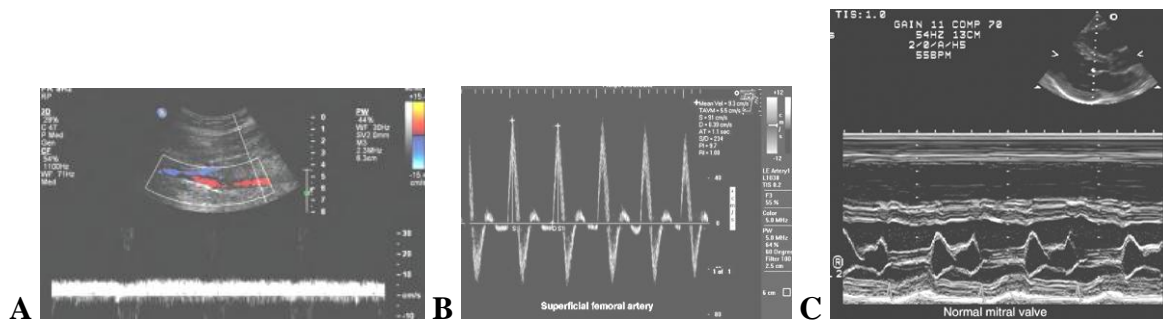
(A) Spectral distribution in venous flow, triplex image, B-color Doppler sector sonogram of thigh at top image. Normal venous Doppler waveforms. Spectral Doppler analysis from the femoral vein demonstrates normal venous spectral signal. The slower flow in this vein gives rise to a wide range of velocities during each time interval. (B) Spectral distribution in plug flow. Pulsed Doppler display for a femoral artery with calculations displayed. A very narrow band of velocities is present throughout the cardiac cycle in this artery. In this case peak systolic and end diastolic velocities are displayed on the real-time image. (C) Duplex US of heart images complex. The insert of B-mode scan (above right of the sector image) of heart shows the orientation of the M-mode image of moved structures normal mitral valve
